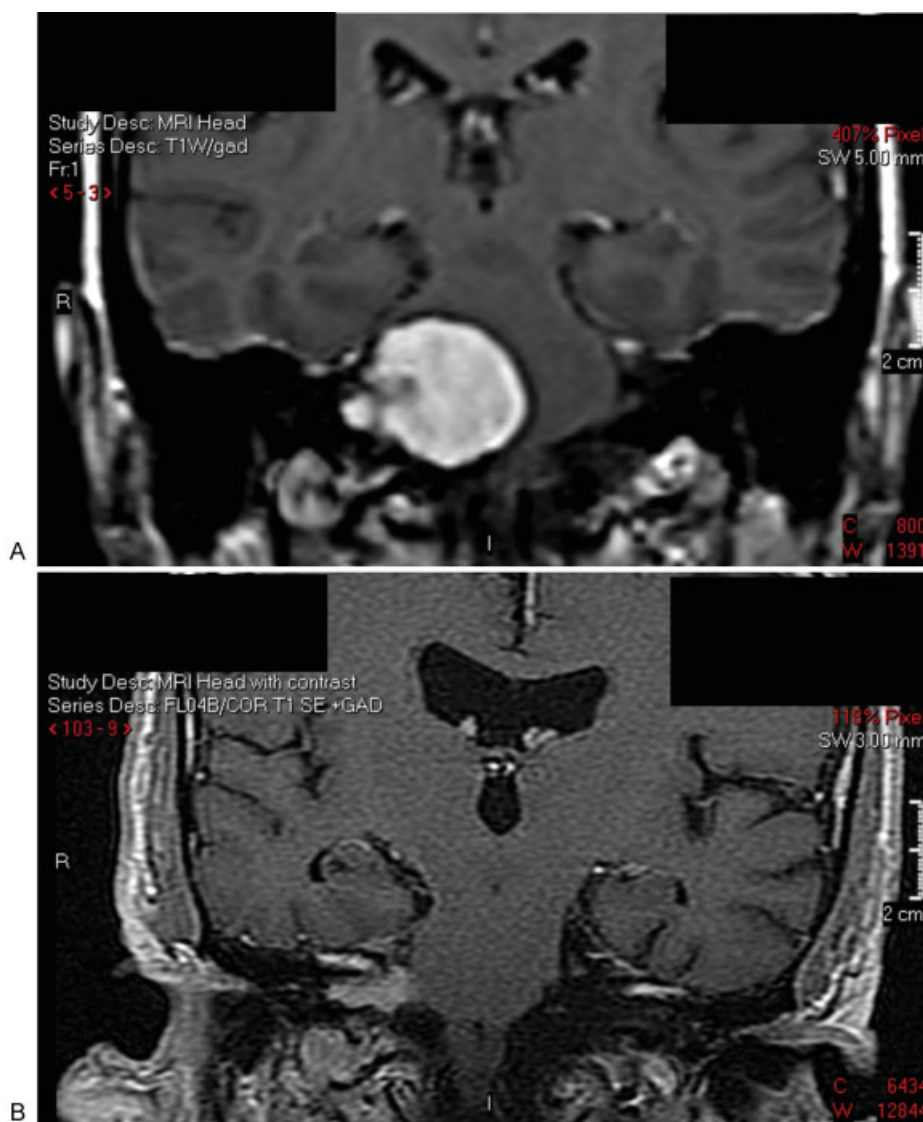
(A) Preoperative image of VS to be excised. (B) First postoperative MR image demonstrating residual VS along the facial nerve and on the brainstem. MR, magnetic resonance; VS, vestibular schwannoma.
